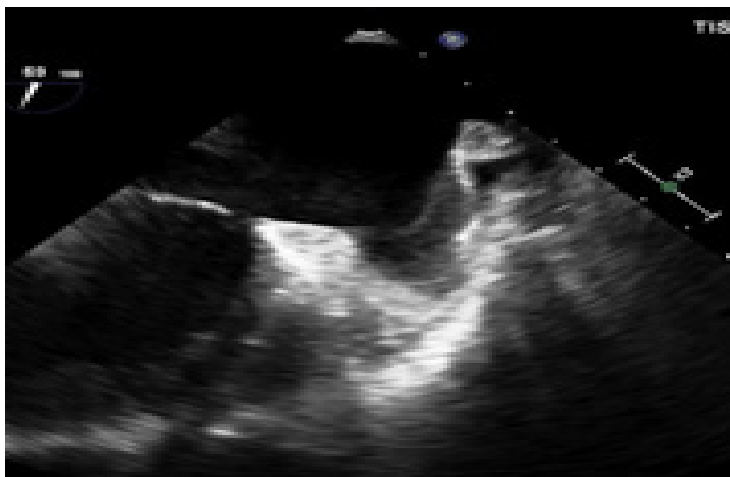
This figure confirms a large thrombus in the left atrial appendage on the intraoperative transesophageal echocardiography.
